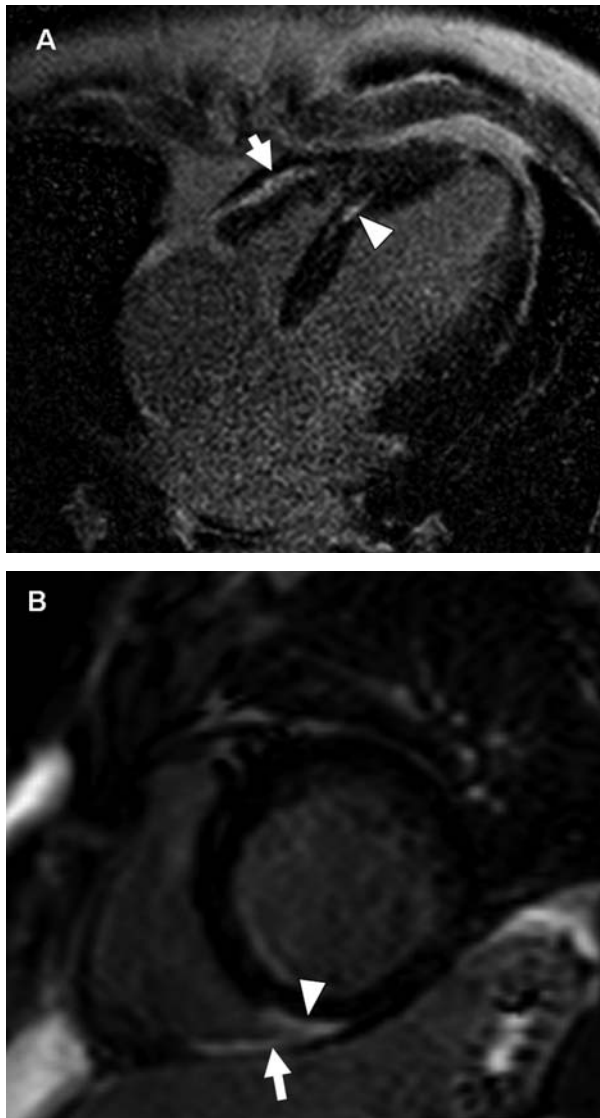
Cardiac magnetic resonance image from another patient, showing delayed hyperenhancement (A) of the right ventricle (arrow) and the interventricular septum (arrowhead) and (B) of the basal inferoseptum (arrowhead) and the adjacent inferior wall of the right ventricle (arrow)
